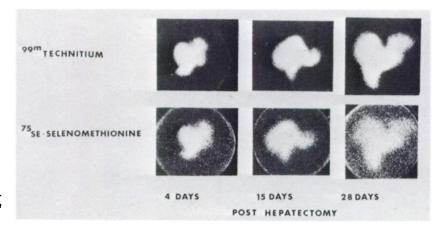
Postmortem TSC and SM scintigraphs showing close similarity of shape and size and distribution of compounds.
